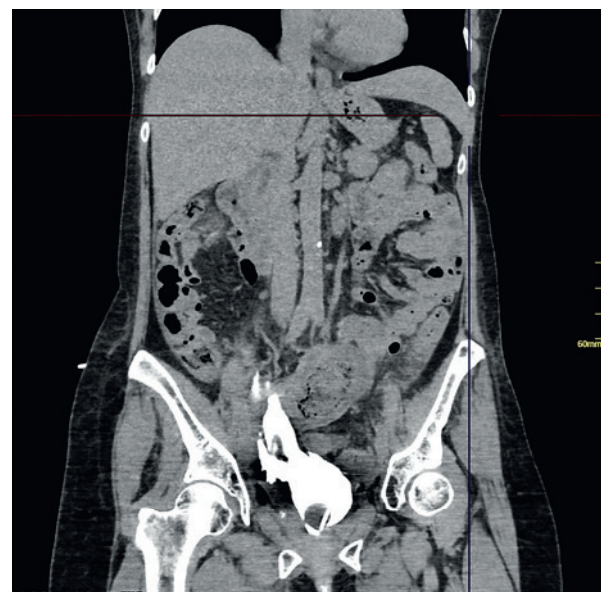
Contrast-enhanced CT. Bladder defect with urine extravasation into the retroperitoneal space
